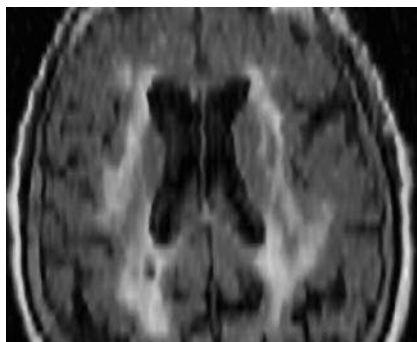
(left). Extensive, deep, white matter disease shown by T1-weighted MRI. Figure 2b (above). The white matter changes shown in Figure 2a are highlighted in a FLAIR MRI sequence.
